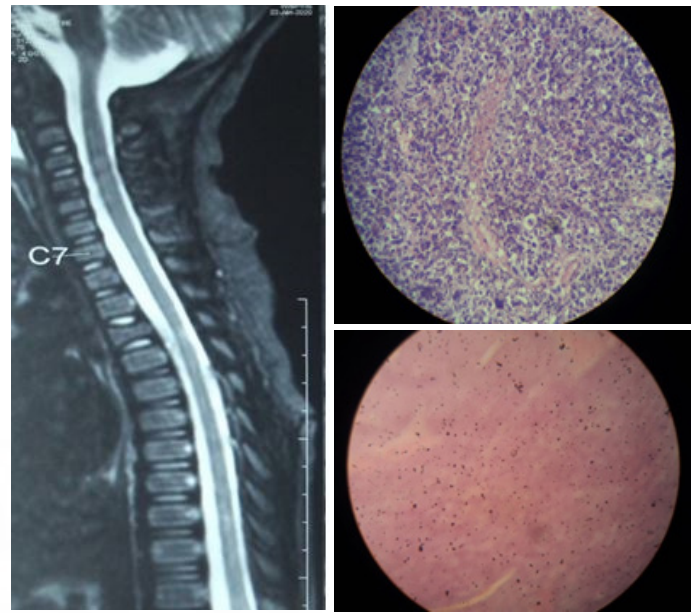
Post operative MRI of whole spine which shows gross total excision with no evidence of regrowth.
